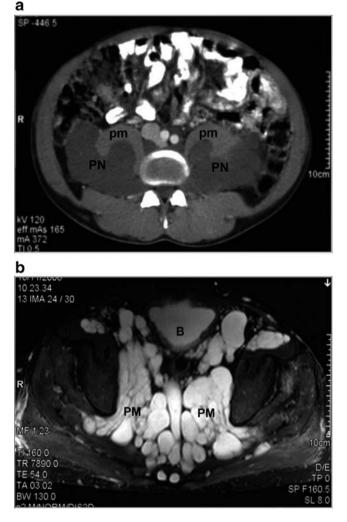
a CT scan view of bilateral retroperitoneal paraspinal bilateral plexiform neurofibromas (PN), compressing and displacing anteriorly the psoas muscle (pm). b MRI view of pelvic retroperitoneal plexiform neurofibromas (PN), hyperintense on T1-weighted images, involving the entire pelvic space. *B* bladder.
